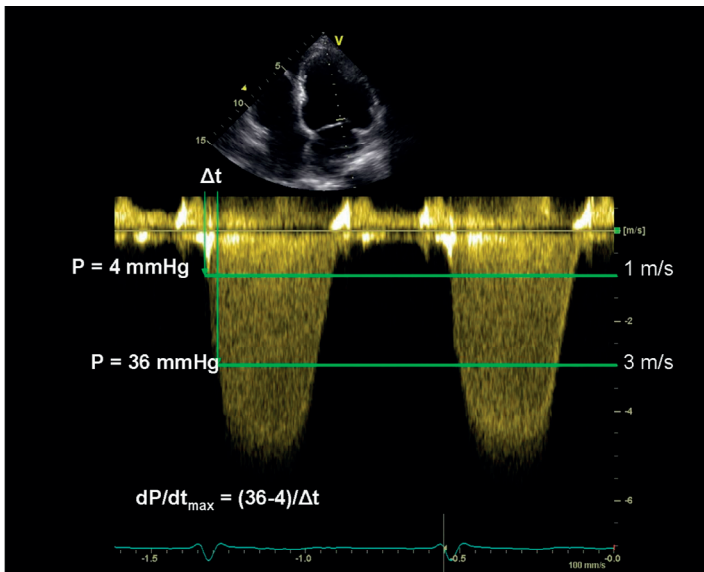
Echocardiographic methods to optimize the AV interval based on LV systolic function. Measurement of LV dP/dt_{max} as indicator of LV performance that permit AV interval optimization.
